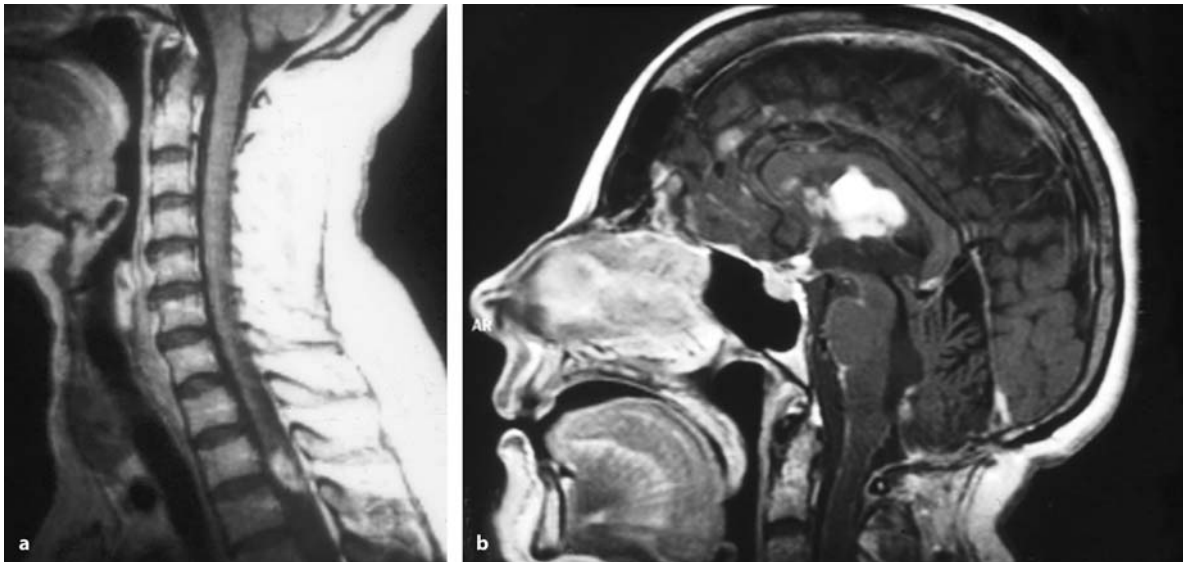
a This sagittal, contrast-enhanced T1-weighted MRI shows an WHO grade III astrocytoma in the conus area of a 28-year-old woman with a 4-week history of a slight paraparesis and no sphincter problems. Despite surgery, and chemo- and radiotherapy, she developed a local recurrence and subarachnoid spreading of the tumor with multiple lesions supra- (b) and infratentorially (c). The patient died 22 months after surgery
